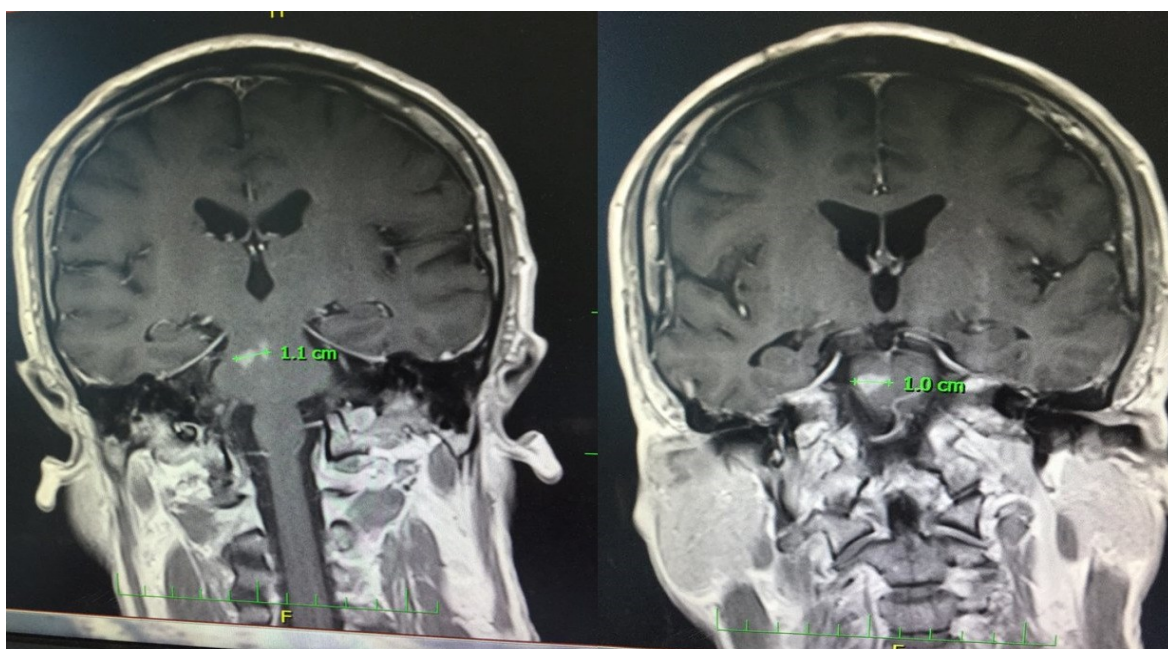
MRI shows 2 layer sections of the brain, a blood clot (Ischemia) in the basilar artery are shown in both layer sections which affected the right pons.
